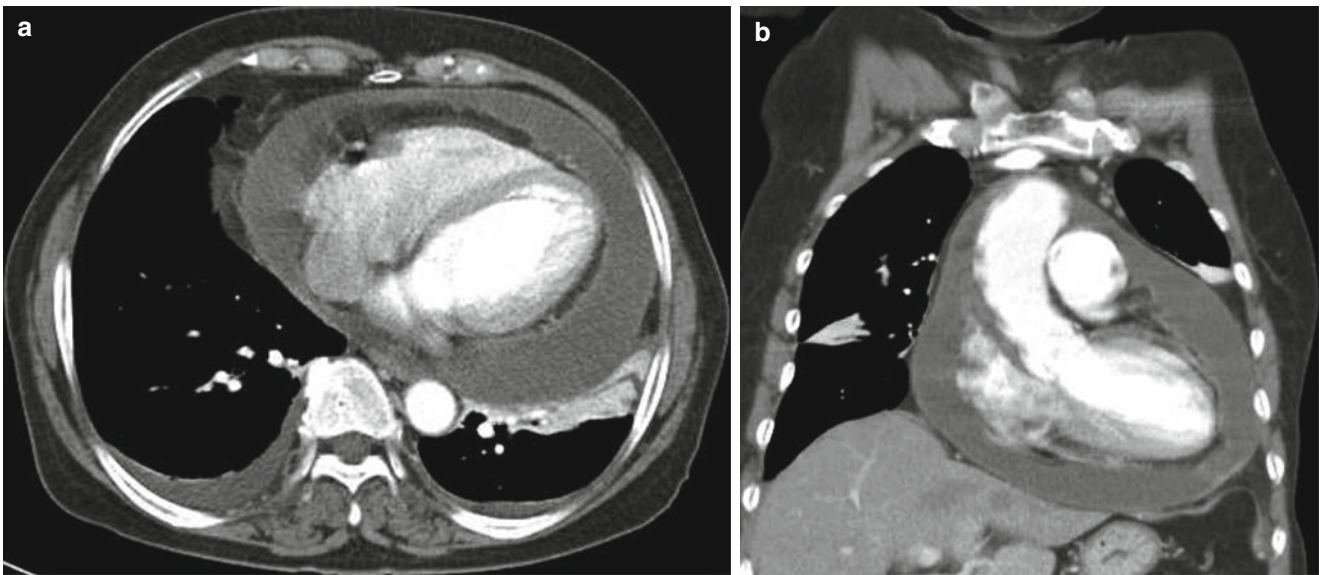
Pericardial effusion. Axial (a) and coronal (b) CT images show large amount of pericardial effusion with a diffusely thickened pericardium. The attenuation of the pericardial effusion is grossly similar to that of pleural effusion
